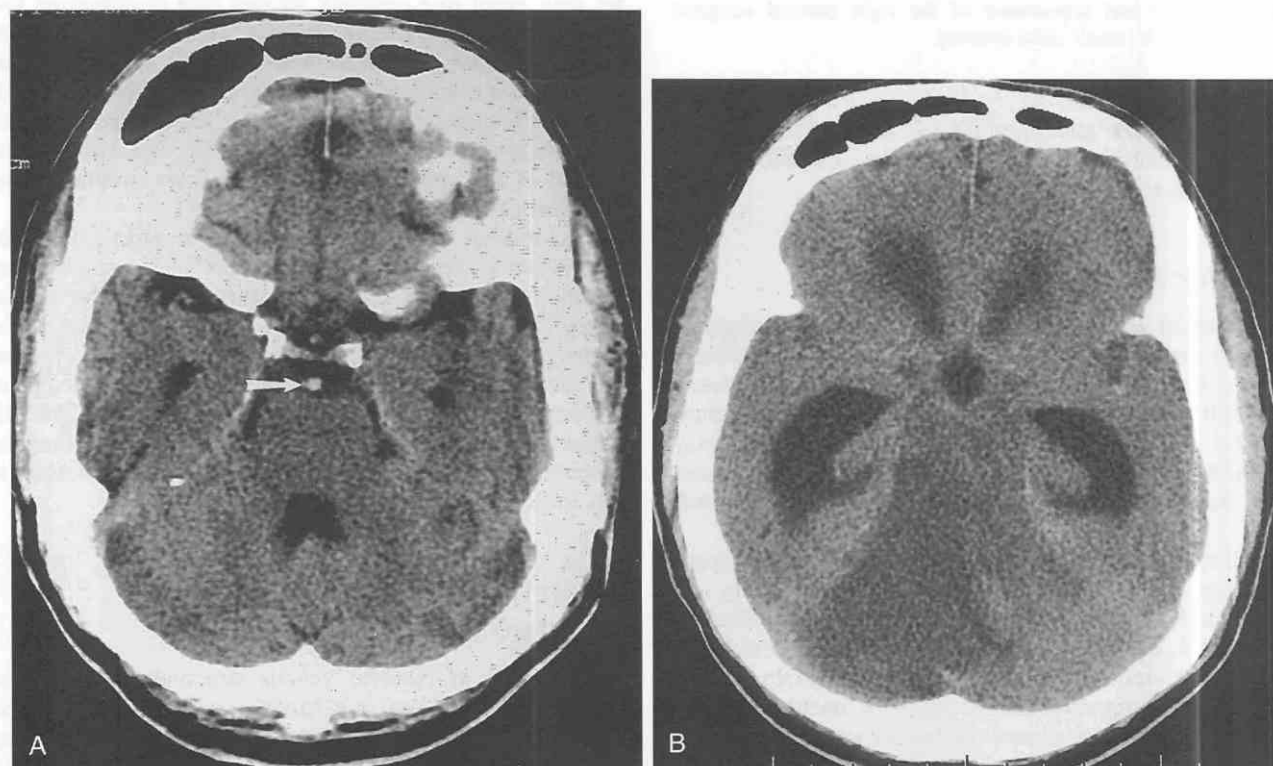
Basilar artery thrombosis. *A*, Unenhanced axial CT image shows increased density within the basilar artery (arrow). *B*, Unenhanced axial CT the following day shows extensive cerebellar hypodensity and hydrocephalus due to fourth ventricular and aqueductal compression.
